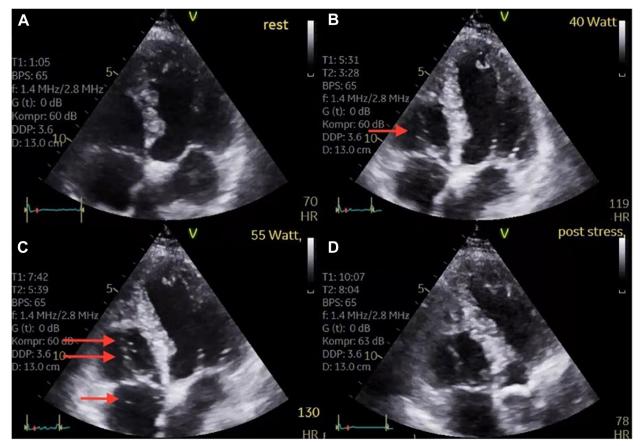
Comparison of apical 4-chamber views (right heart centered) during different stress levels. At stress levels 40 watts (B) and 55 watts (C), echogenic bubbles appear only in the right atrium and right ventricle (*red arrows*). Bubbles are not recorded at rest (A) or in the late recovery period (D).
